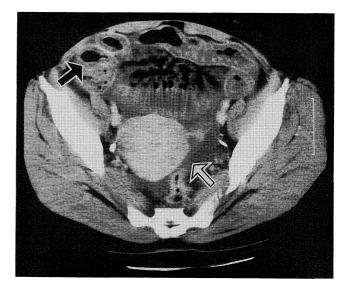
The findings of an abdominal CT scan. The abdominal CT scan showed ascites (white arrow), and marked wall thickening and dilatation of the lower intestine. The black arrow indicates the construction of three layers in the small intestine.
